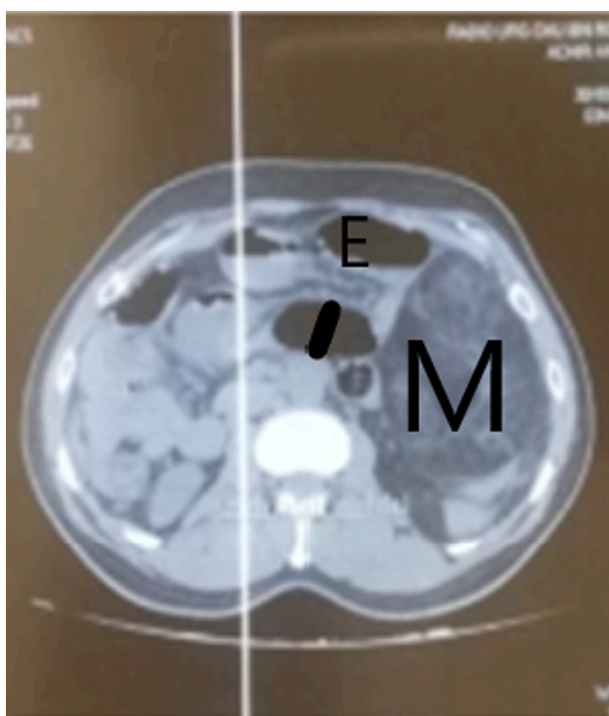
Abdomen CT scan image showing a fatty mass in the abdomen (M) the stomach € with jejunum distension (black line).
